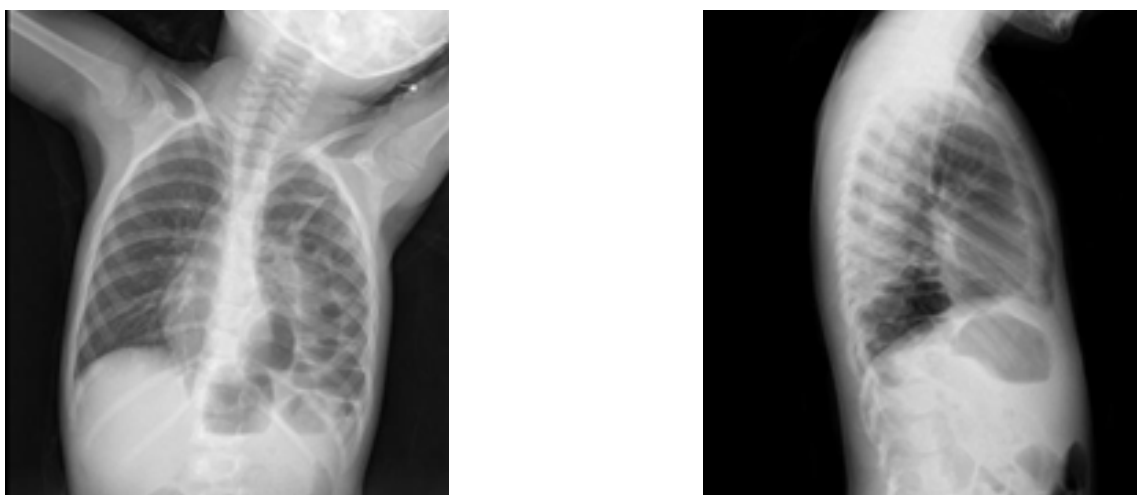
Thoracic and abdominal radiograph showing bowel loops in the left hemithorax in a) anteroposterior view and b) lateral view.
